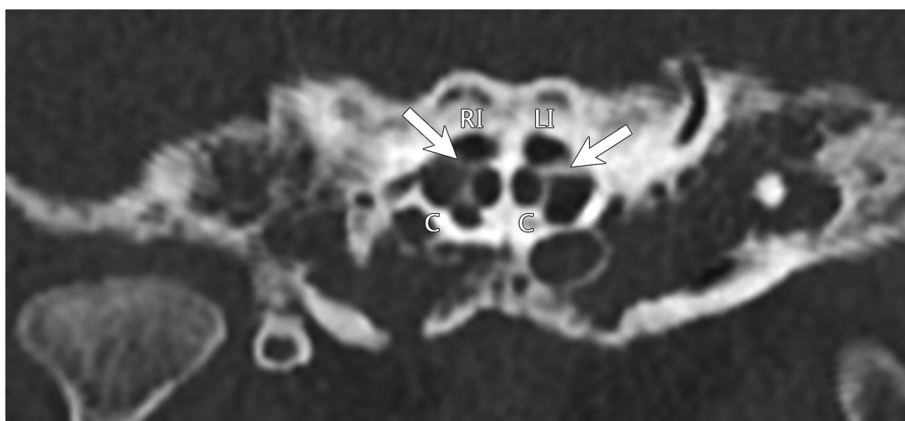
Coronal oblique view passing through the cochlear aperture level of temporal bone CT. Abbreviations: Arrows, cochlear aperture region; C, cochlea; LI, left internal acoustic canal; RI, right internal acoustic canal.
